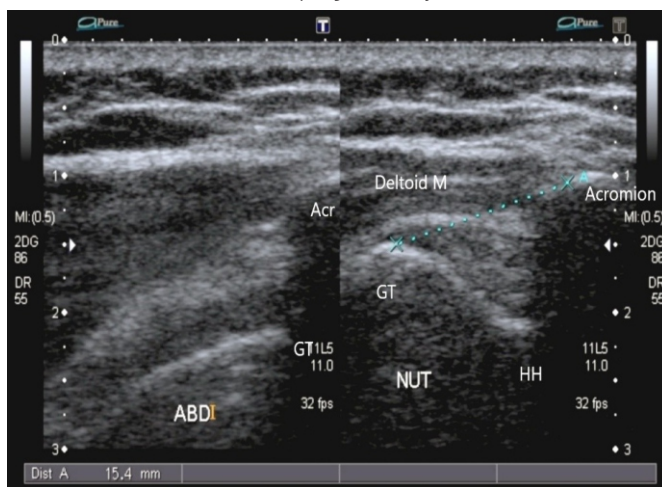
Ultrasound image of the normal right shoulder during abduction and neutral position. In the right-sided image, the distance from the acromion to greater tuberosity was measured the neutral position which is 15.4mm. In the left-side image, the greater tuberosity disappears beneath the acromion
